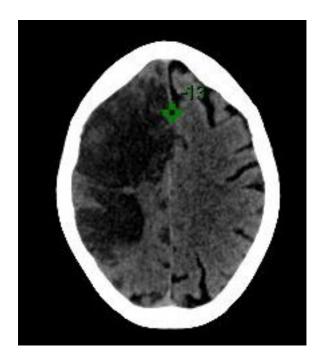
CT noncontrast axial showing falx lipoma.
